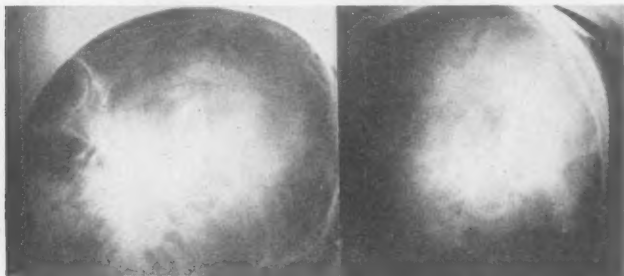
May 14, 1924: Roentgenologic examination of both mastoid processes reveals a normal pneumatic process and cellular structure of both sides. (Legend by Dr. Post.)
